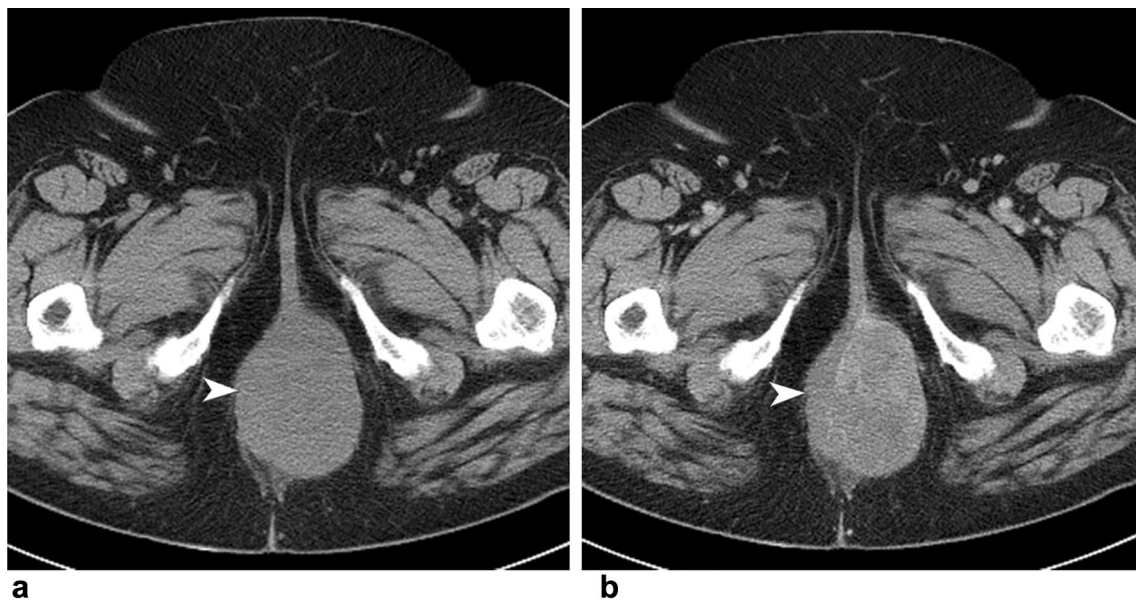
69-year-old female presents with buttock discomfort while sitting. Axial precontrast (a) and contrast-enhanced (b) CT images of the pelvis show the large hypodense mass (white arrowheads) within
